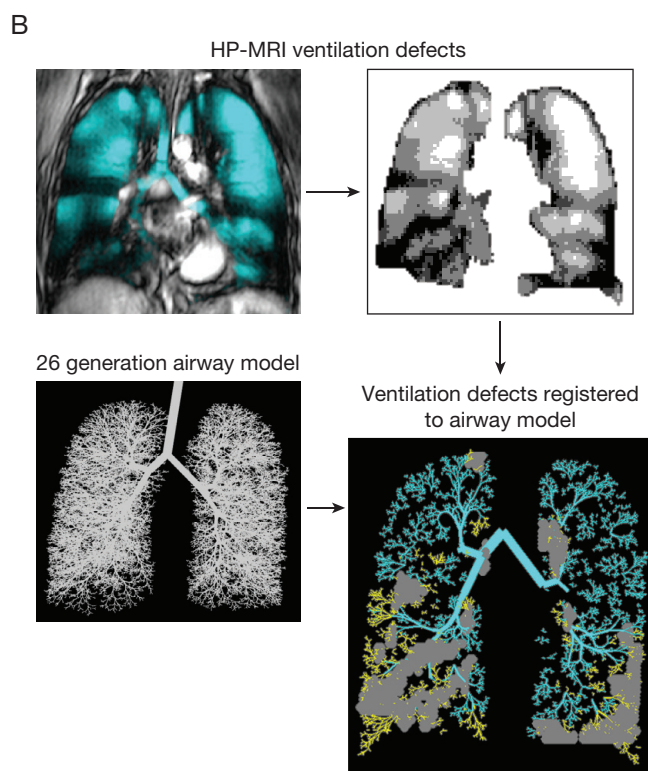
Combining structural and functional small airways assessments may provide better disease characterization. A, Helium-3 MRI co-registered with helium-1 MRI and CT imaging. Blue coloring indicates helium-3 MRI ventilation; green indicates parametric response mapping-determined healthy tissue; yellow indicates gas trapping indicative of small airways disease; and red indicates emphysema. B, Co-registration of HP-MRI and airway mesh model with plethysmography. Blue indicates ventilated areas of the lung; yellow indicates areas of defective lung ventilation. fSAD = functional small airways disease; HP-MRI = hyper-polarized gas MRI. Images in panel A taken from Capaldi DPI, Zha N, Guo F, Pike D, McCormack DG, Kirby M, Parraga G. *Radiology*. 2016;279:597-608.¹⁴⁴ Copyright © 2016 with permission from the Radiological Society of North America. Images in panel B reproduced with kind permission from Dr Grace Parraga, Robarts Research Institute, Western University, Ontario, Canada.)
